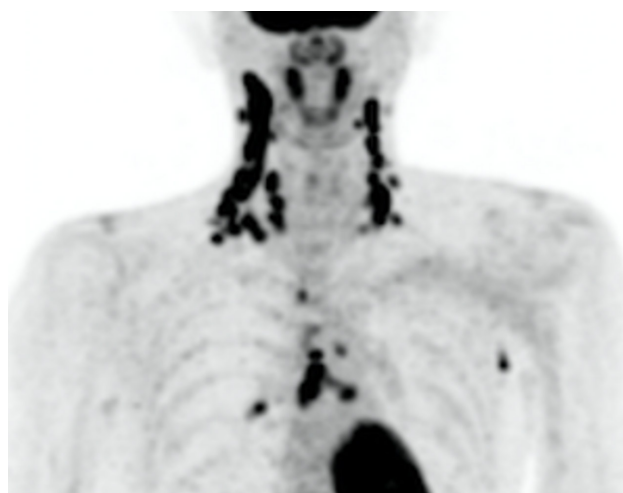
FDG-PET showed highly accumulated uptake in the lymph nodes of the mediastinum as well as the neck and axillary region.
